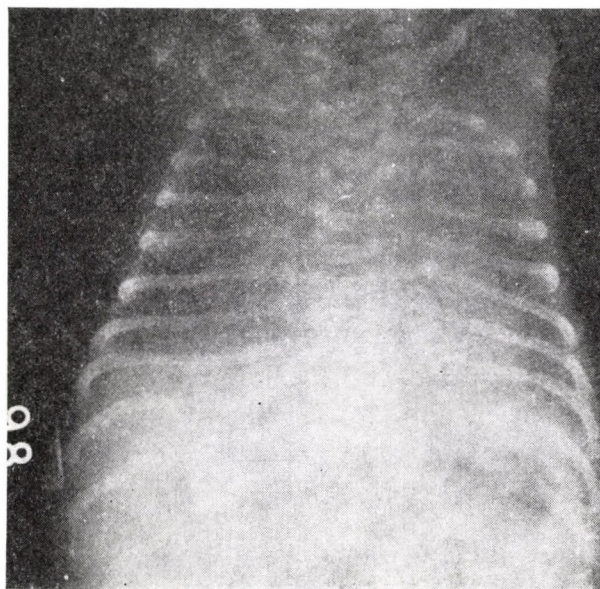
Case 1 Chest X-rays at 1.5 hours of life
